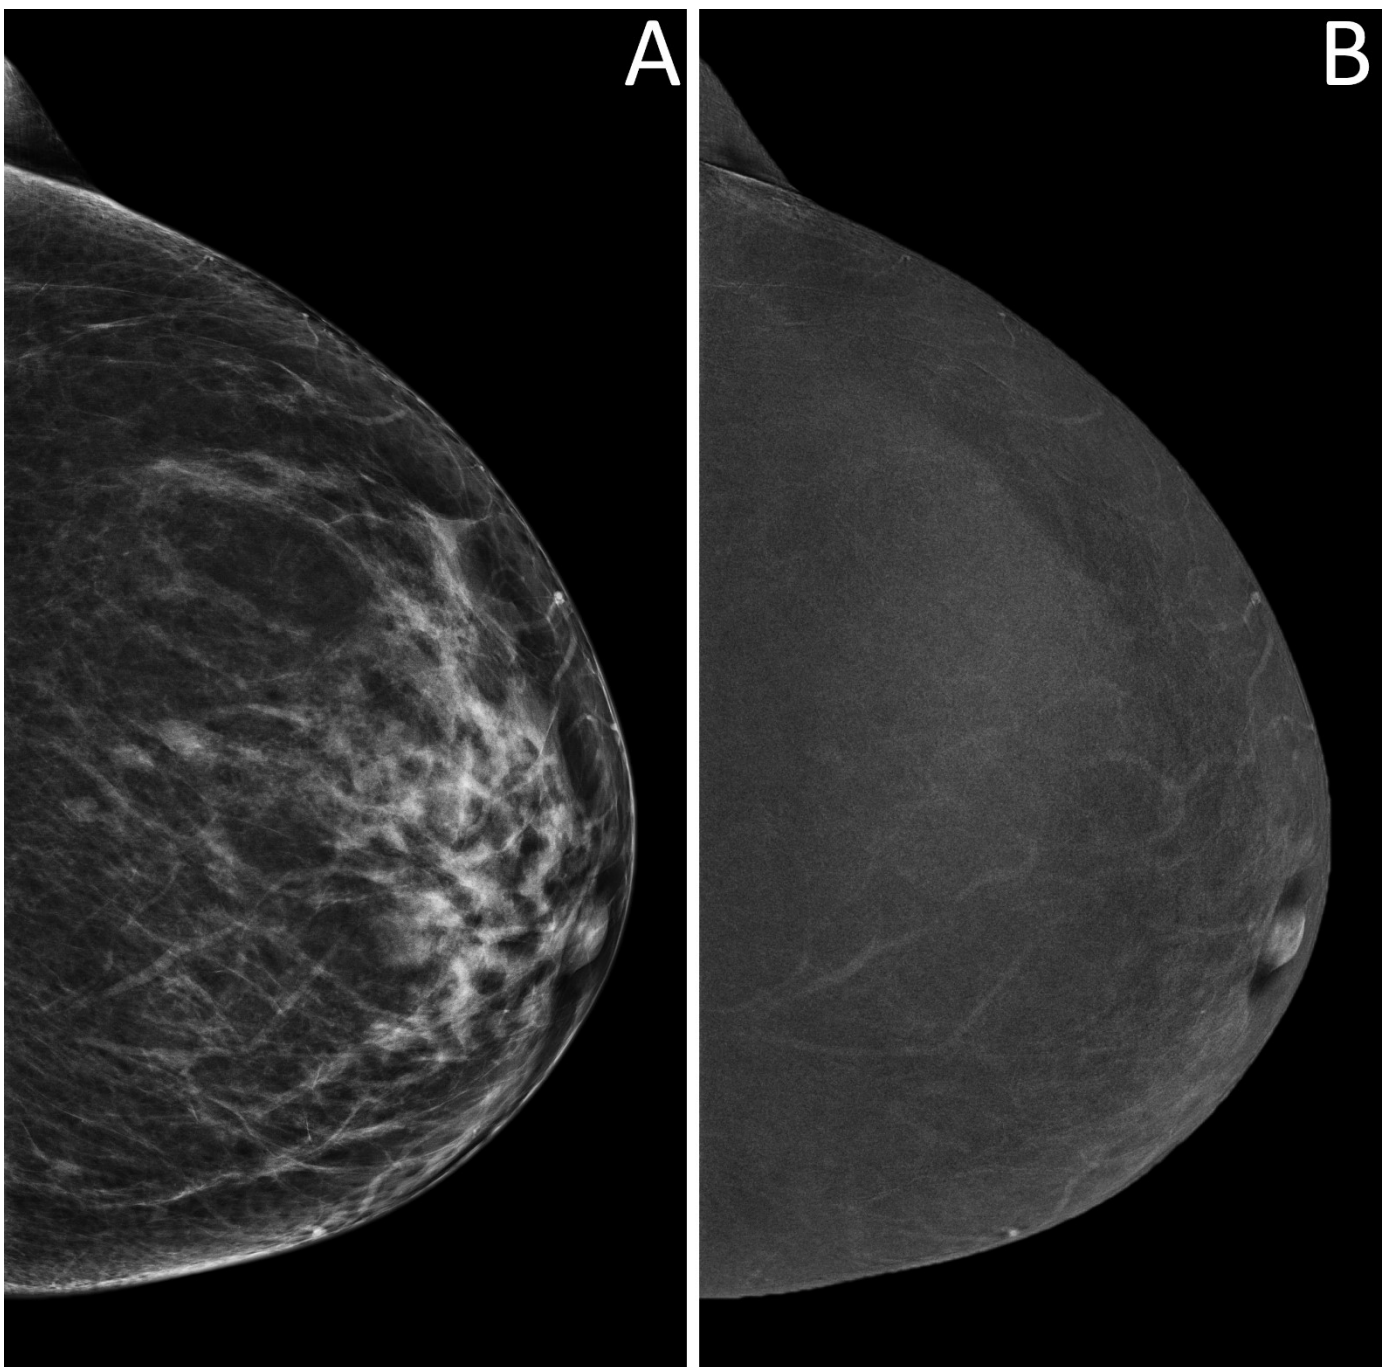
True negative case at CEM. A 58-year-old woman was recalled for a suspicious retroareolar irregular opacity in the right breast, detectable only on the craniocaudal view (panel A, light blue rectangle), whereas the mediolateral oblique view does not show any suspicious finding (panel C). An ultrasound-guided core needle biopsy was performed, leading to a diagnosis of apocrine metaplasia. The absence of enhancement foci on recombined images, both in correspondence of the suspicious opacity on the craniocaudal view (panel B, light blue rectangle) and on the mediolateral oblique view (panel D) would have oriented the referral to follow-up
